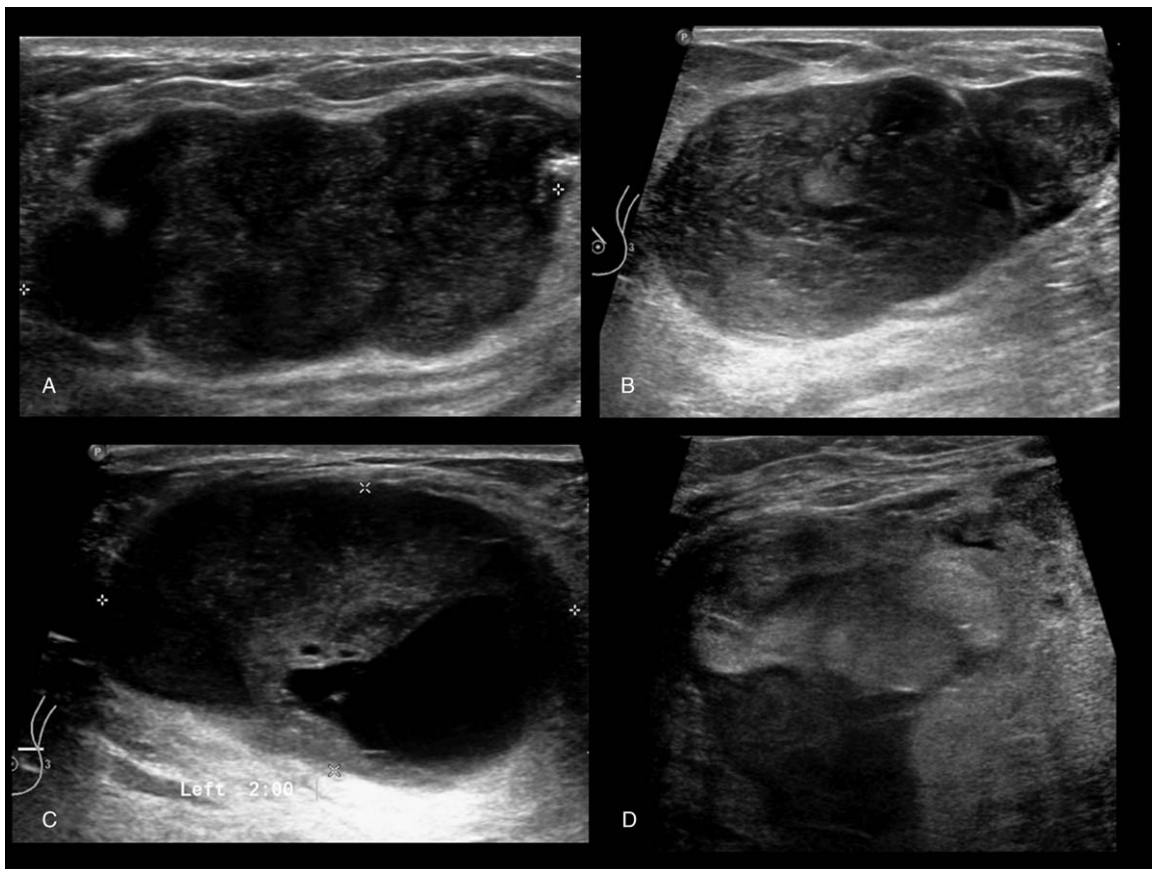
Ultrasound images showing (A) benign PT with lobulated margin (B) Malignant PT with well-defined border and posterior acoustic enhancement. Malignant PT with (C) cystic spaces, (D) heterogeneous internal echo. PT=phyllodes tumor.
